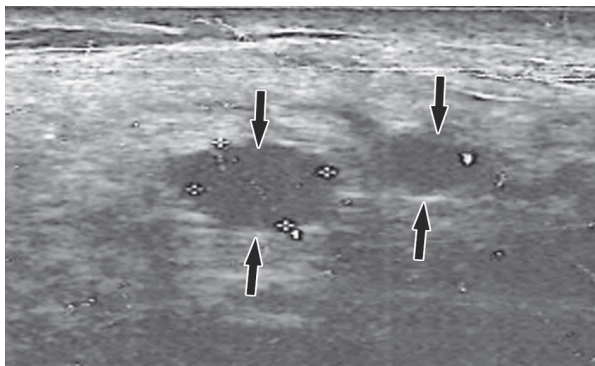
Ultrasound of right breast showing multifocal breast carcinoma with 2 ill-defined hypo-echoic mass lesions in the right upper quadrant (arrows).
